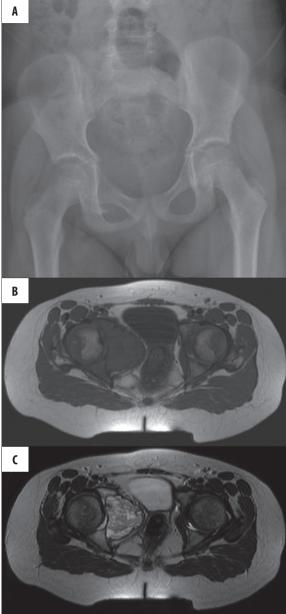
Patient B.J. (A) Plain film. Suspected malignant tumor of the right pubic bone. Ill-defined mass around the pubic bone, Codman's triangle. (B,C) MRI. ABC of the pubic bone: no signs of malignancy, well-defined mass, hypointense on T1WI (A), inhomogenously hyperintense on T2WI (B).
